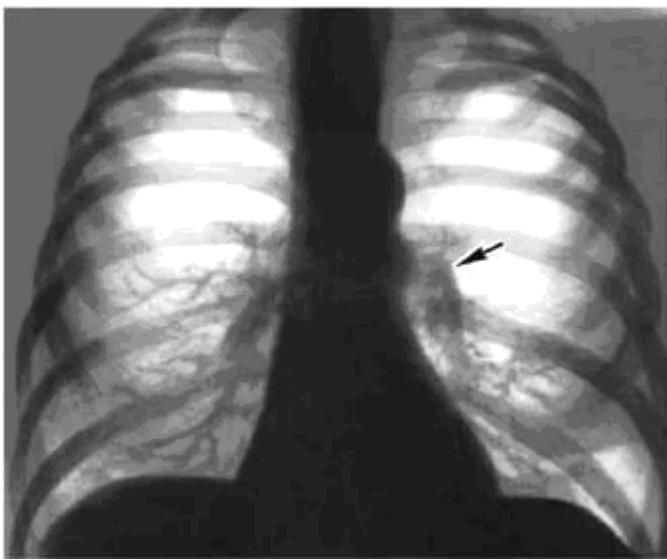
Chest radiograph of a patient with pulmonary emphysema and cor pulmonale: the heart is relatively small, the pulmonary artery conus (indicated by the arrow) is prominent, the hila are enlarged due to dilation of major pulmonary arterial branches, and the peripheral vascular pattern is diminished.
